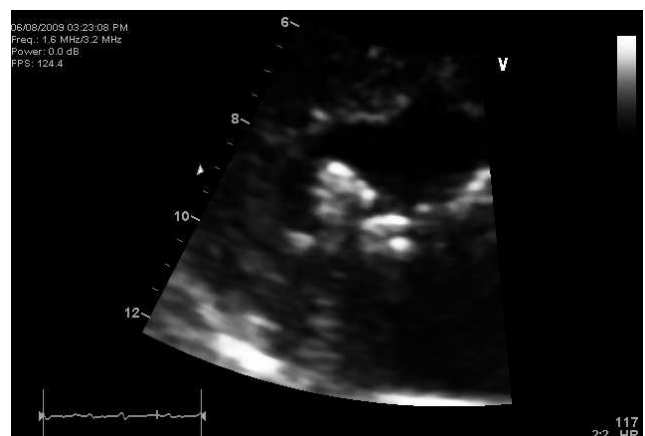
2-dimensional echocardiogram.
